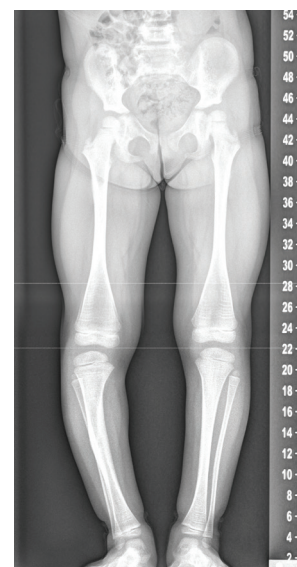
This X-ray of the patient at 4 years old shows that her hips are located and maturing normally.
